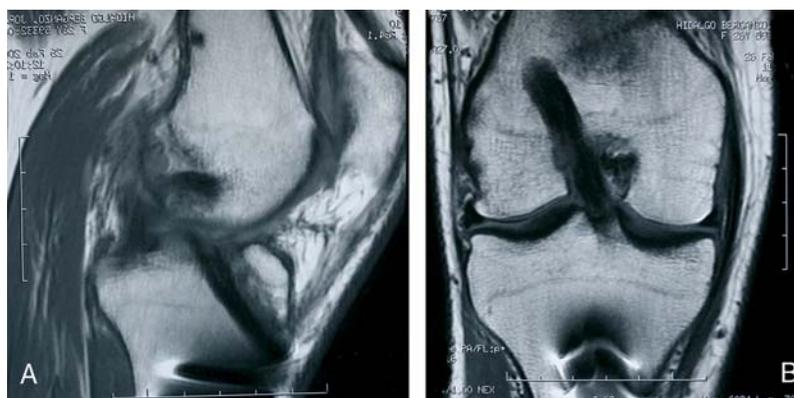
Magnetic resonance imaging aspect of the tibial (A) and femoral (B) tunnels 4 months after anterior cruciate ligament surgical reconstruction.
